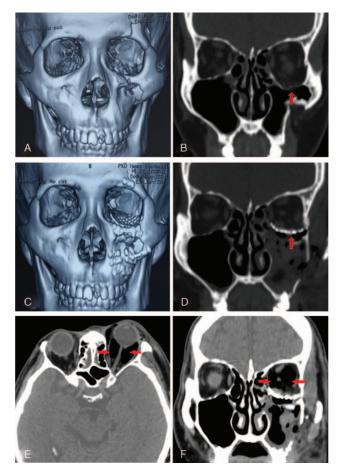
(A) Three-dimensional computed tomography (CT) scan showing left zygomaticomaxillary complex fracture and left inferior orbital wall fracture. (B) Coronal CT scan showing left inferior orbital wall fracture (arrow). (C) Three-dimensional CT scan showing osteotomy reduction of the left zygomaticomaxillary complex fracture and reconstruction of the left inferior orbital wall. (D) Coronal CT scan showing orbital floor reconstruction with titanium mesh (arrow). (E) Coronal soft-tissue scan on the 5th operative day showing extensive presence of air in the left orbit region (arrows). (F) Axial soft-tissue scan on the 5th operative day showing extensive presence of air in the left orbit region (arrows).
